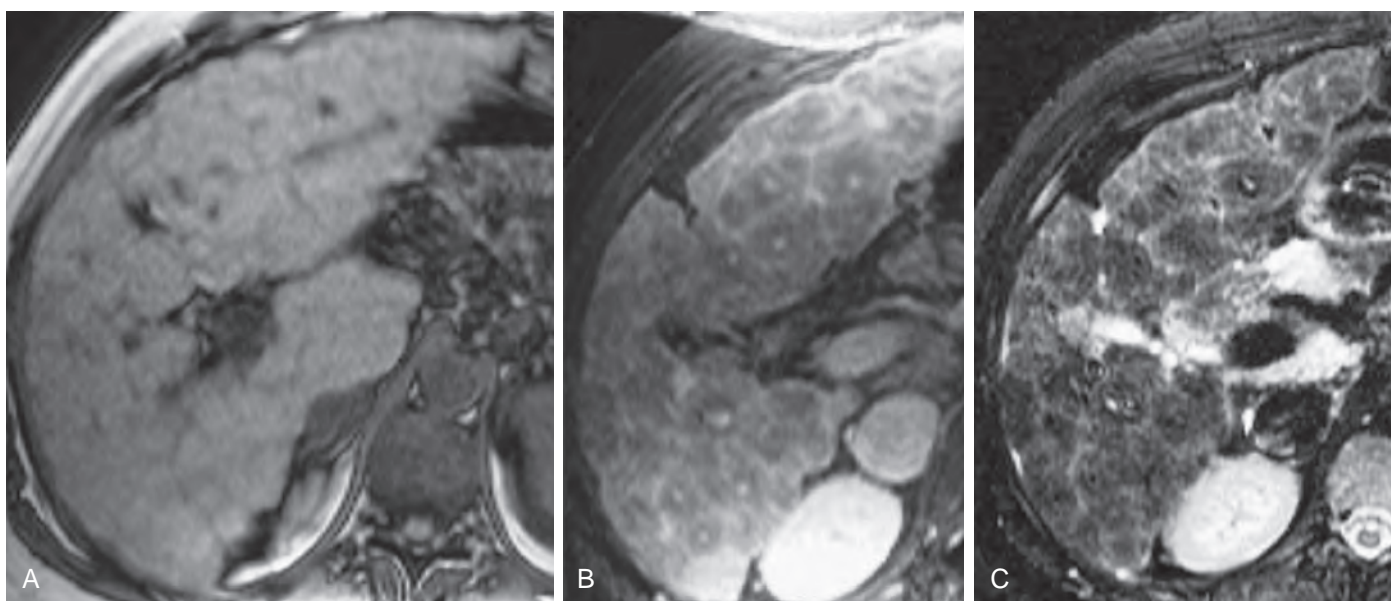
Primary biliary cirrhosis: MR findings. A. T1-weighted, unenhanced MR image shows numerous small regenerative nodules. B. T1-weighted MR image obtained 3 minutes after infusion shows conspicuous areas of low signal intensity around portal veins. C. T2-weighted single-shot fast spin-echo MR image reveals round areas of low signal intensity encircling portal veins.
